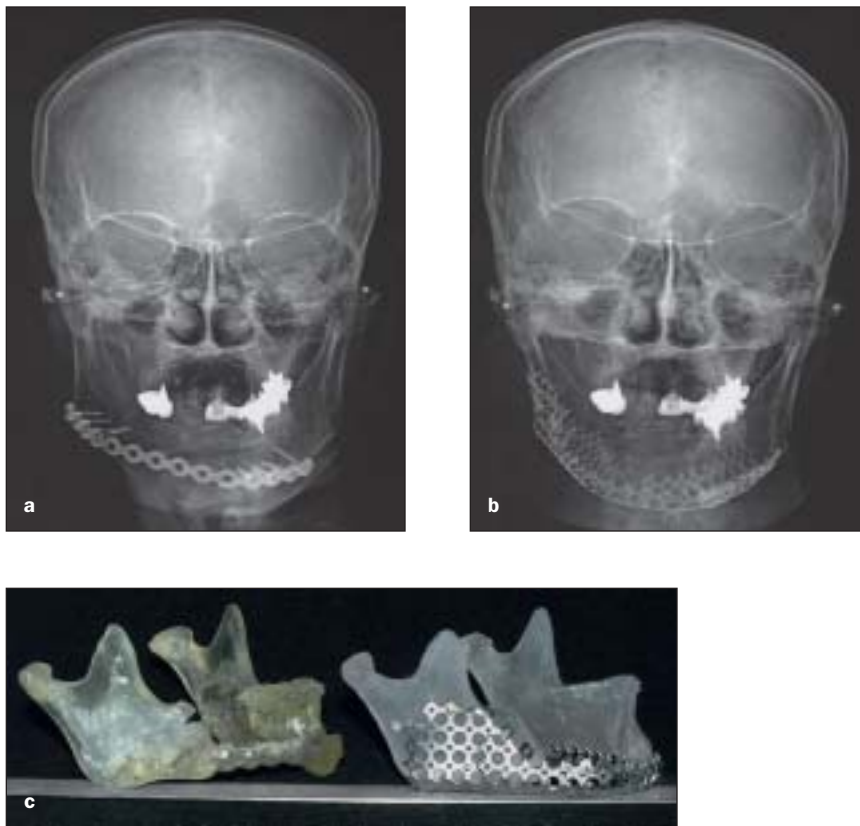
Postoperative radiograph (a) after primary reconstruction with reconstruction plate and (b) after secondary reconstruction by this technique. (c) Left, displacement of the residual mandible bone by reconstruction plate. Right, a mandibular model after proper reproduction of the shape by this technique.
